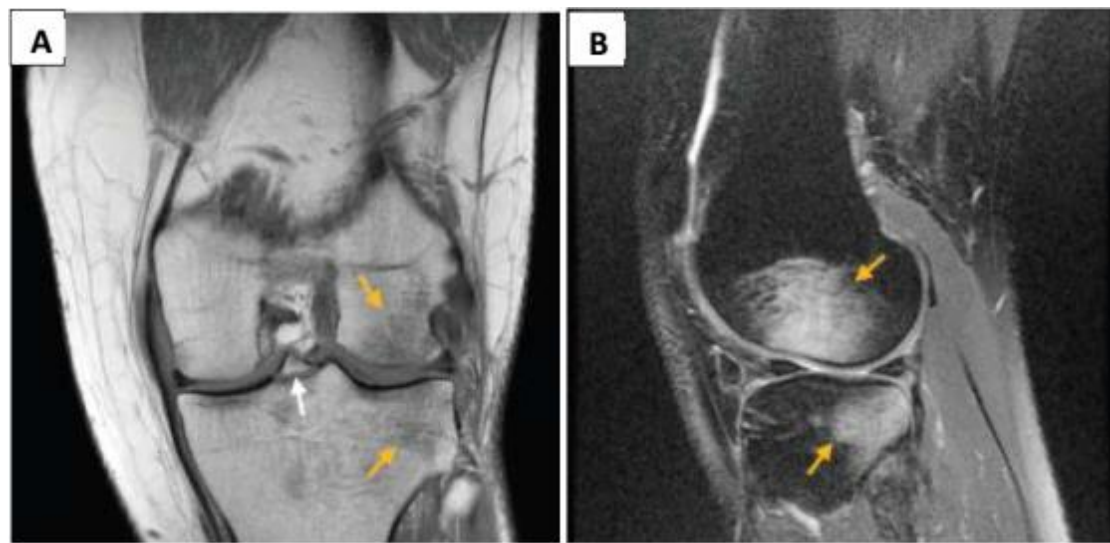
A: T1-weighted coronal view magnetic resonance image demonstrating a medial tibial spine avulsion fracture (white arrow). Bone marrow edema was also noted in a pivot shift injury pattern involving the lateral femoral condyle and the lateral tibial plateau (orange arrows). B: T2-weighted fat-suppressed sagittal view magnetic resonance image demonstrating bone marrow edema in a pivot shift injury pattern involving the anterior lateral femoral condyle and posterior lateral tibial plateau (arrows). (16)
